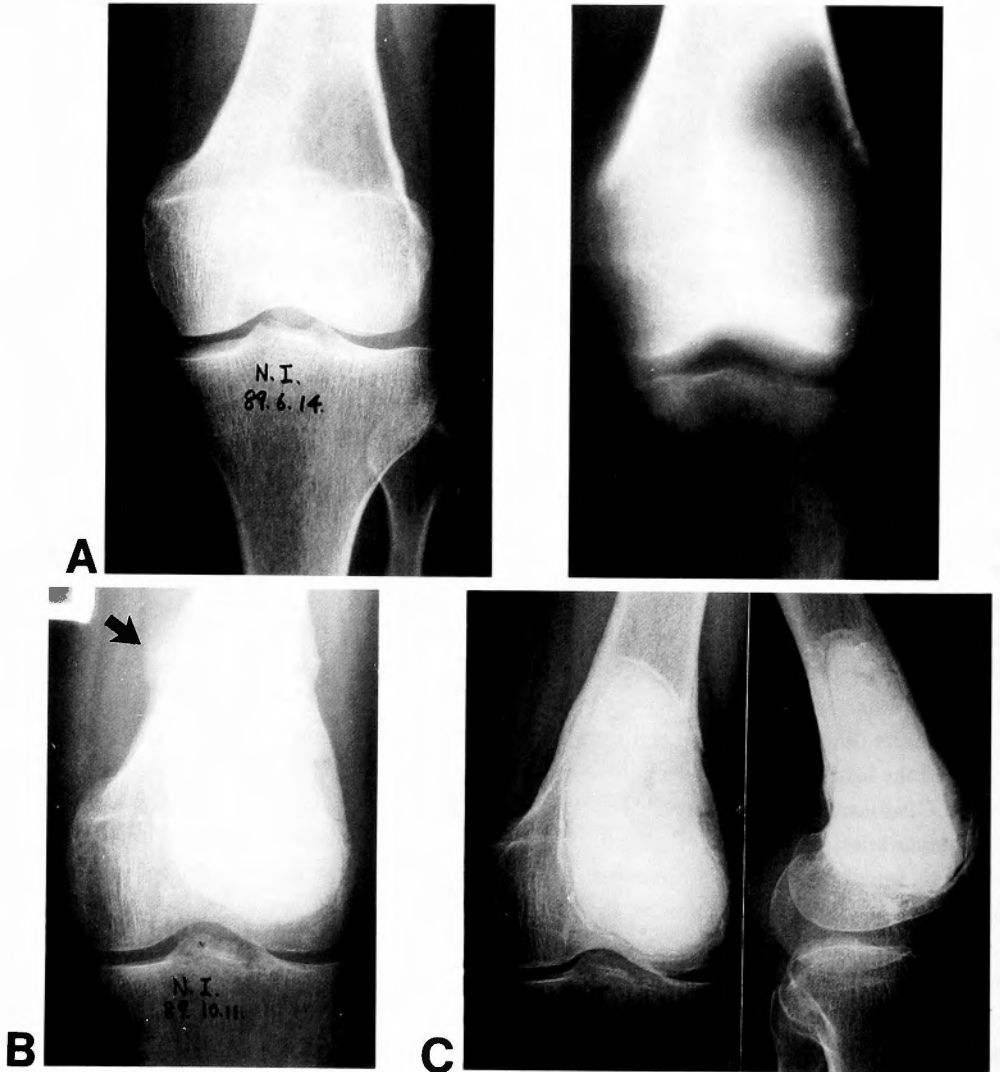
Case 6. 48 year old female. GCT at the distal femur (A). Two months after the operation, this patient suffered from a pathologic fracture. A callus formation was visible on x-ray examination (arrow) (B). X-ray taken 36 months after the operation (C). According to a modified functional evaluation system, this case was rated as excellent.
